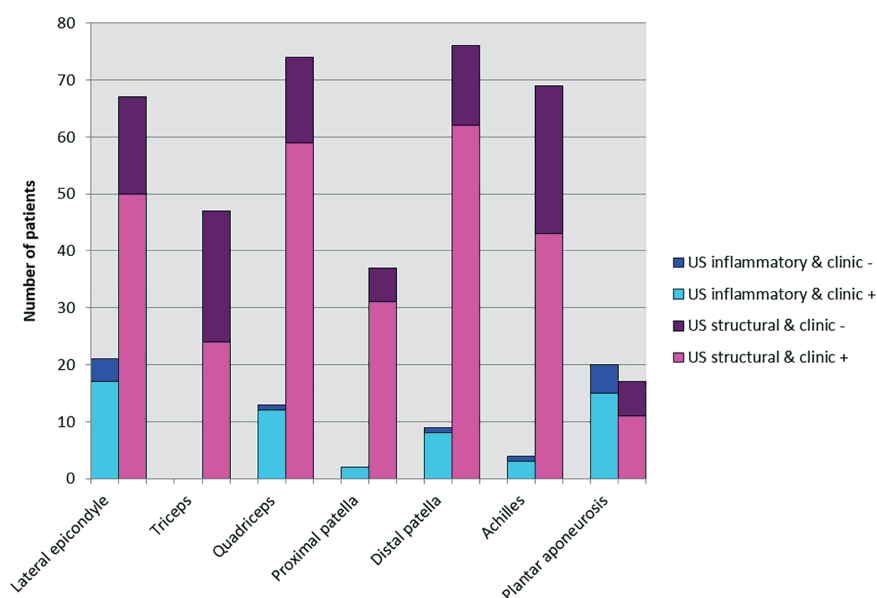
Distribution of the ultrasound findings, both structural changes (US structural) and active inflammation (US inflammatory), in combination with the clinical findings (- = negative; + = positive) at each enthesal site (US = ultrasound).
